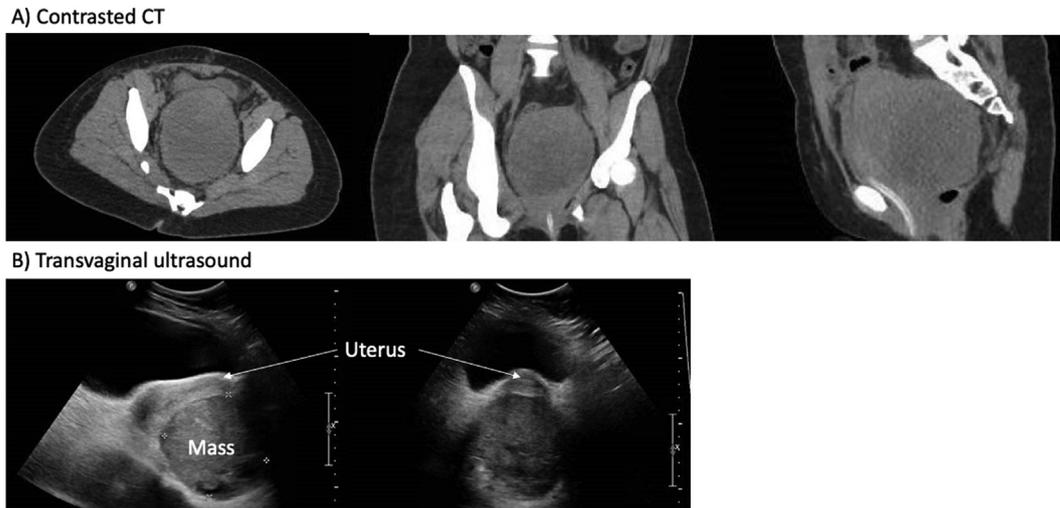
Pelvic imaging of uterine mass with a) CT and b) transvaginal ultrasound.
